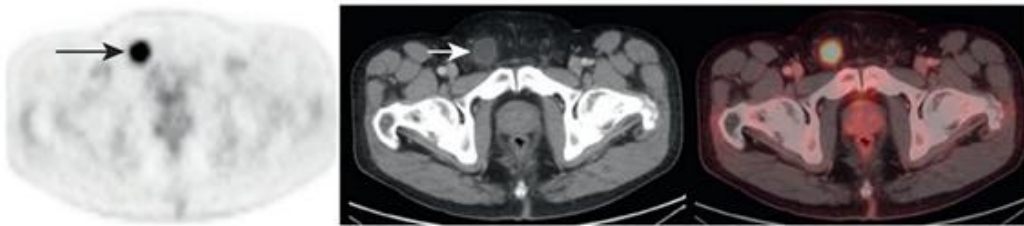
Axial FDG PET, CT, and fused FDG PET/CT through the pelvis of a patient with lymphoma. The FDG-avid focus on the PET-only image (*arrow*) is at first glance suspicious for a malignant node. However, on the corresponding CT image, the lesion has attenuation equal to water (*short arrow*). This is unusual for a lymphoma node and prompts further evaluation.
